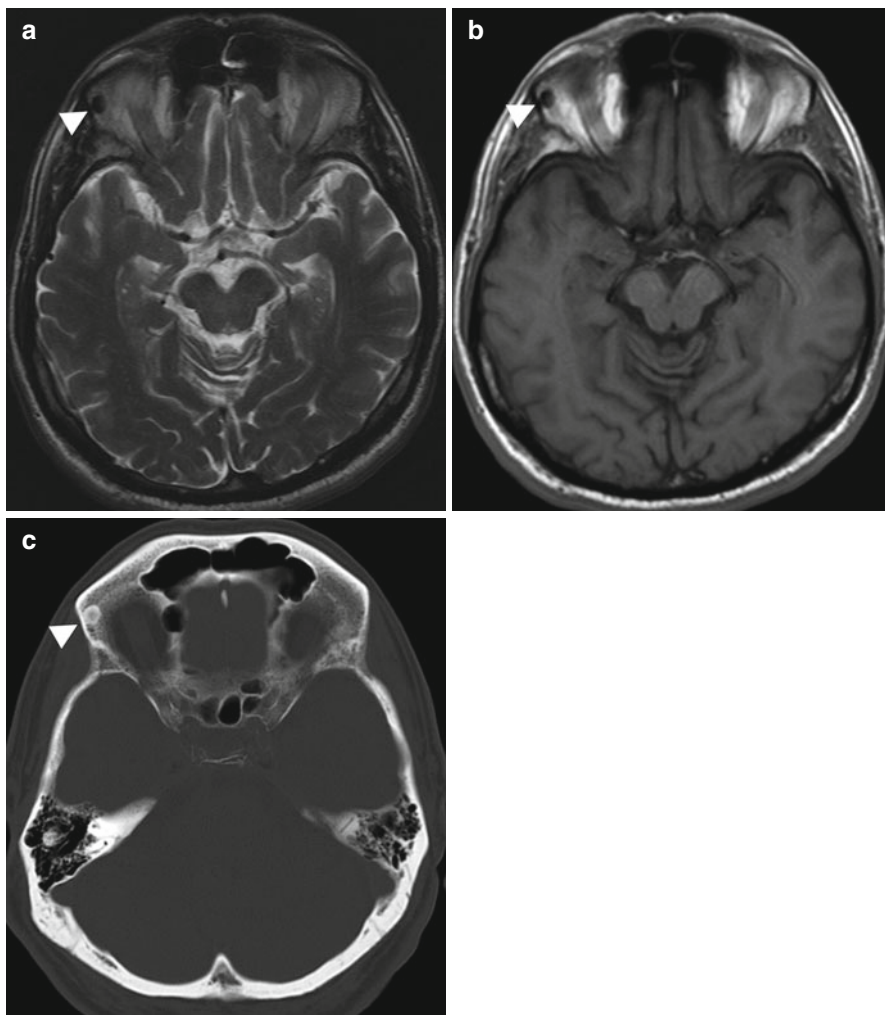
Incidental screening finding and diagnostic workup. Sixty-five-year-old male subject with a sharply delineated, oval lesion (*arrowhead*) in the right orbital roof. The lesion has low signal intensity on axial T2w TSE image (a) and axial T1w SE image (b). Diagnostic workup with CT (c) demonstrates a homogeneously calcified lesion, consistent with an osteoma
